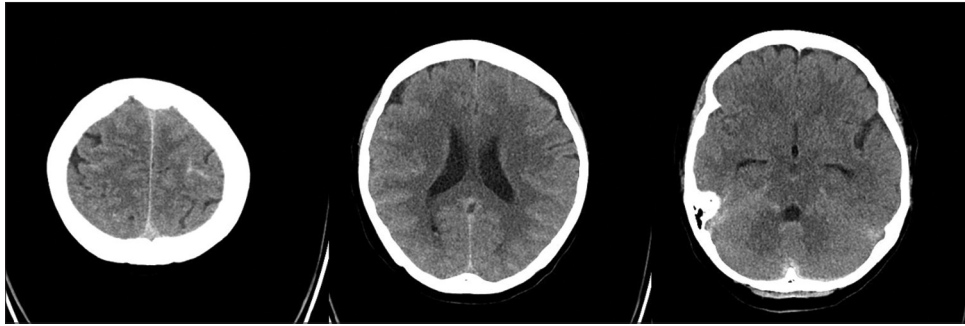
Computed tomography of brain showed the subtle subarachnoid hemorrhage and intra-ventricular hemorrhage extended from spinal hemorrhage
